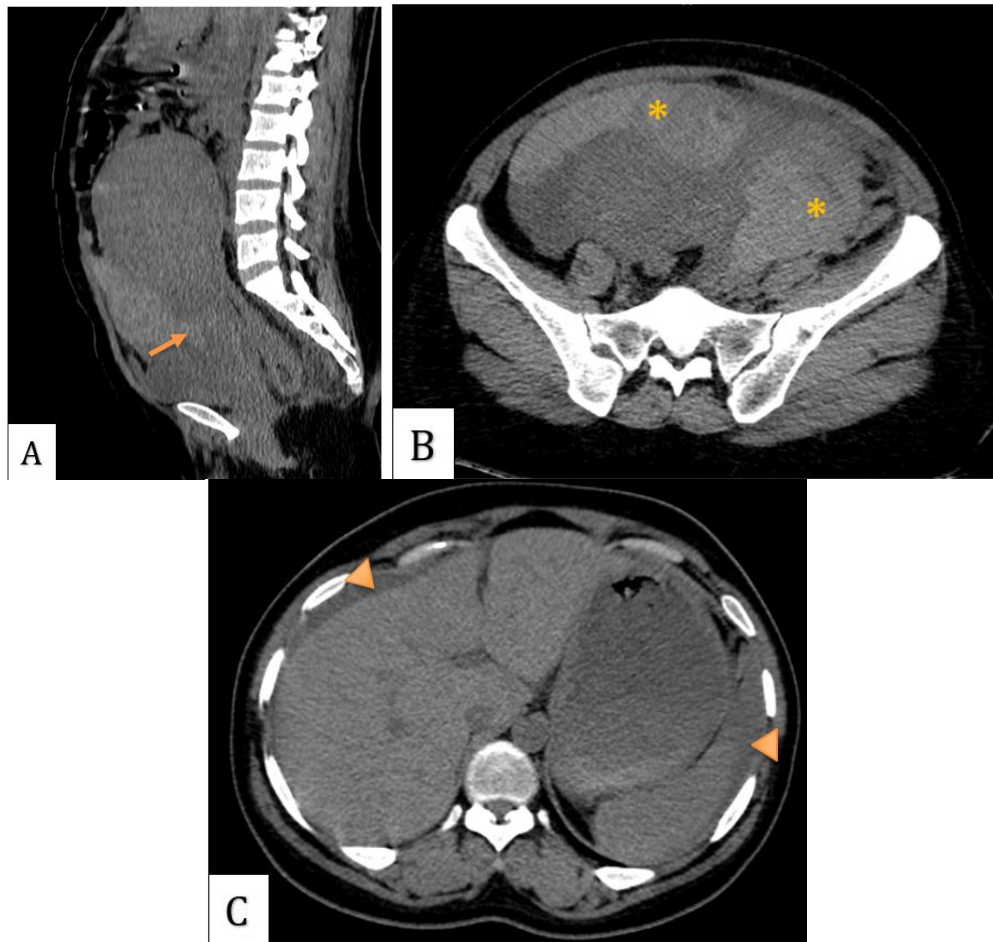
Non-contrast pelvic CT scan with sagittal and axial view showing the anterior wall rupture (A) (arrow), extensive hematoma (B) (asterix), and hemoperitoneum (C) (arrowhead)
